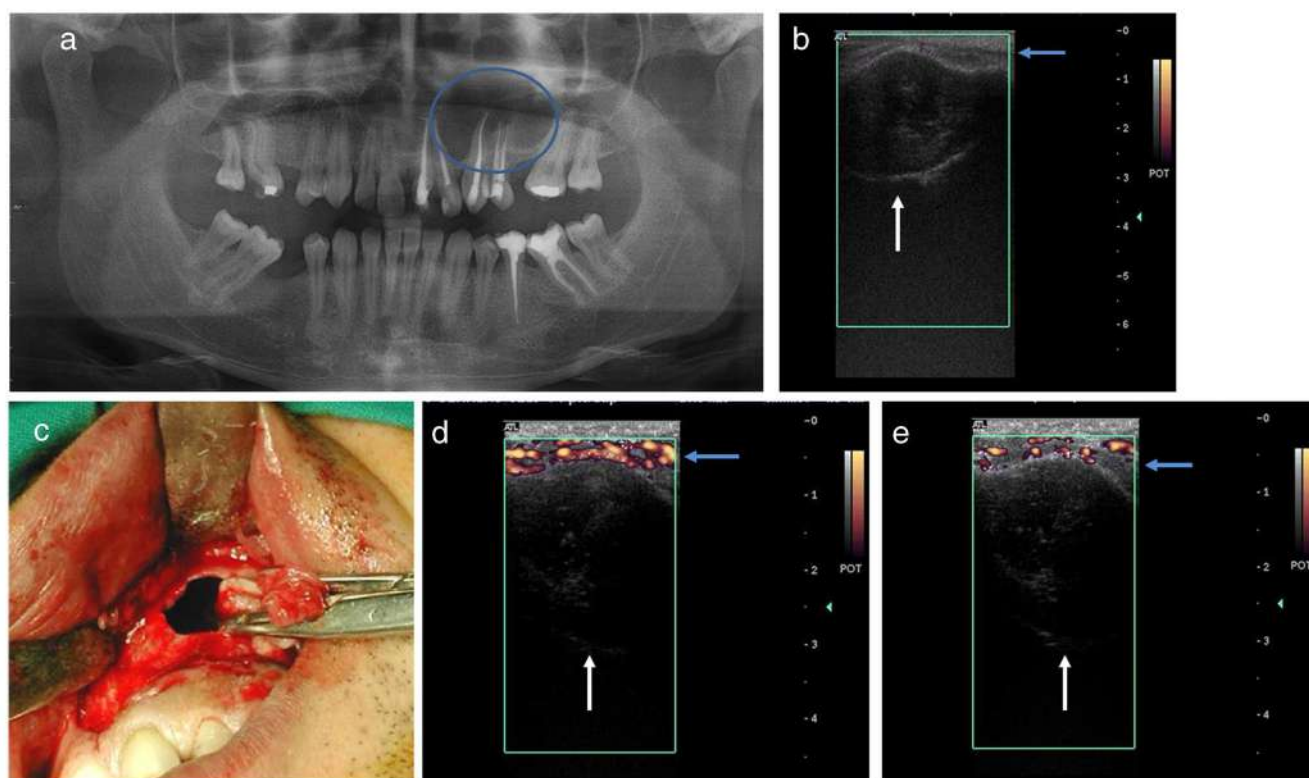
Positive control. a Orthopantomography showing apical periodontitis involving teeth no. 10, no. 11, and no. 12 (circled). b Preoperative US-CPD showing absence of vascularity (blue arrow). c Clinical view of the endodontic surgery. d US-CPD at 1 week from
